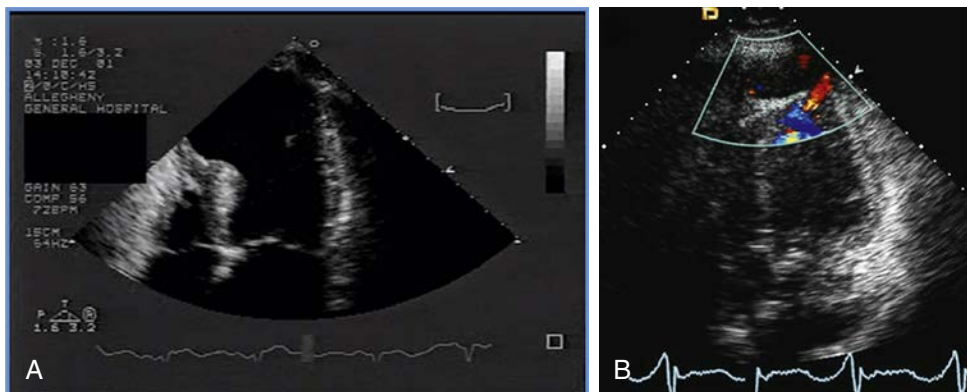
Echocardiography is useful at differentiating (A) left ventricular (LV) aneurysm (wide entry neck) from (B) an LV pseudoaneurysm (narrow entry neck). (From Tsang MG, et al: *Echocardiography in acute myocardial infarction*. In Lang RM, et al, editors: *ASE's comprehensive echocardiography*, 3rd ed. Philadelphia, Saunders, 2016.)
